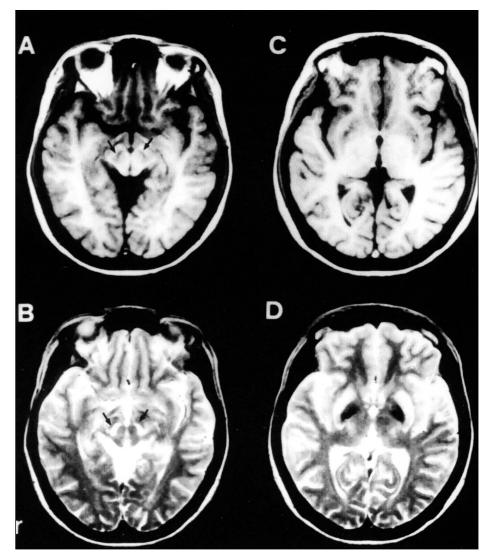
Brain magnetic resonance images (MRI) revealed decreased signal intensity lesions at the midbrain, particularly the substantia nigra (arrows) on T1W (A). On T2W, the substantia nigra lesions showed hyperintensity (arrows) (B). Brain MRI also showed low signal intensities on T1W in the putamen of the basal ganglion (C). On T2W, the basal ganglia revealed hyperintensities in the putamen and hypointensities in the globus pallidus (D).
